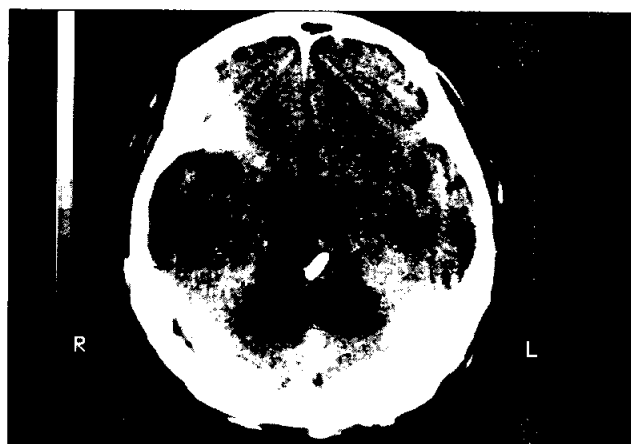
Post-operative computed tomographic scan of the patient with ventricular catheter in the cyst demonstrating the collapse of the cyst wall.
